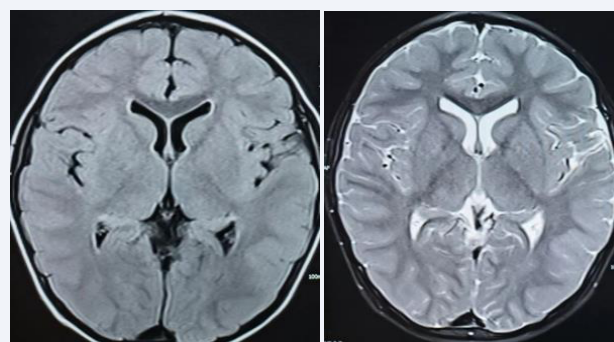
T1(left) and T2(right) weighted images of unenhanced cross-sectional MRI of the child's head.
